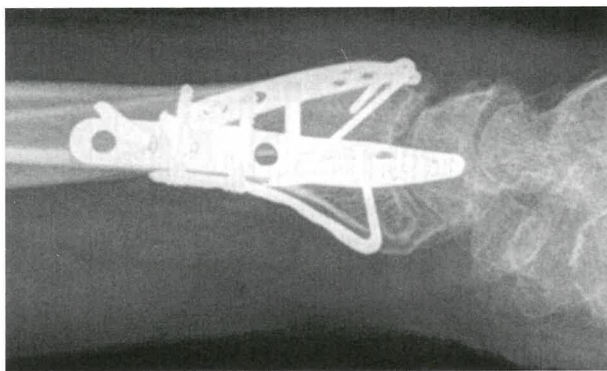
Radiograph showing a third-generation plate with a thinner profile at the hook bend.
